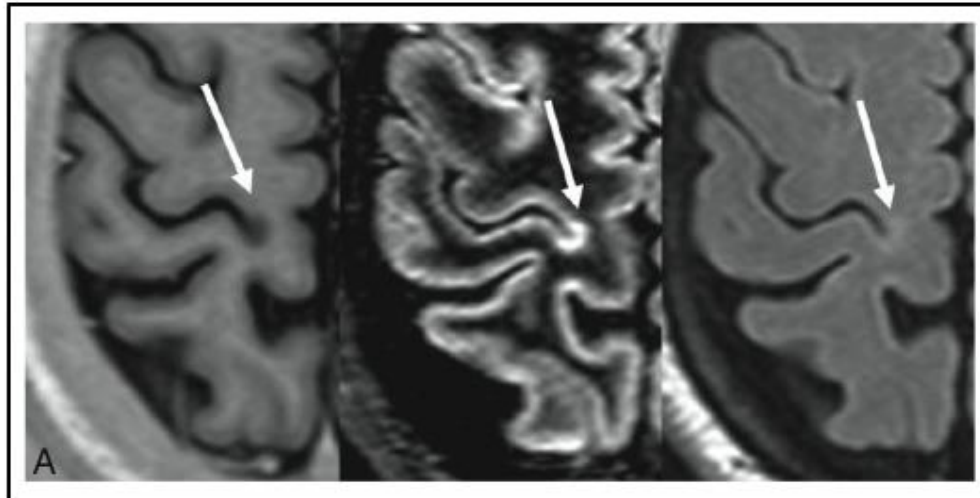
Improved detection of intra-cortical lesions (white arrow) using phase sensitive inversion recovery (PSIR, left) in combination with double inversion recovery (DIR, middle), compared to conventional fluid attenuated inversion recovery (FLAIR, right). Images kindly shared by Dr Flavia Nelson, Associate Professor of Neurology at the University of Texas, Medical School at Houston.
